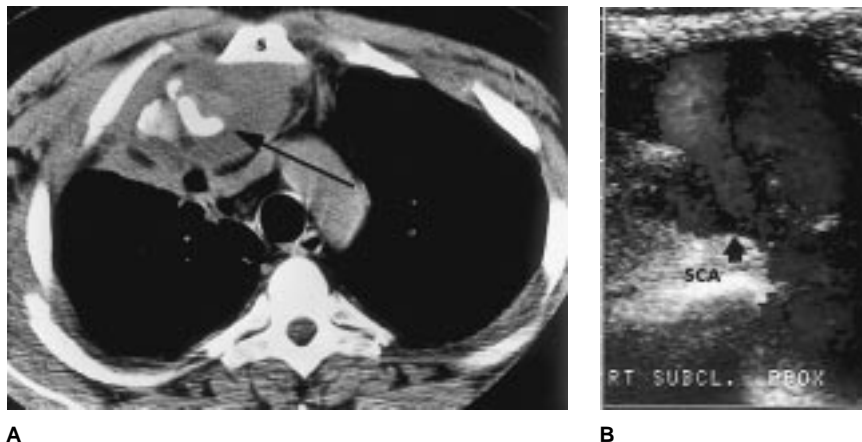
A, CT scan revealing a posterior fracture-dislocation of the sternoclavicular joint with significant soft-tissue swelling and compromise of the hilar structures. Note the comminuted medial-clavicle fracture (arrow). S = sternum. B, Duplex ultrasound study revealing a large pseudoaneurysm of the right subclavian artery (SCA). Note the large neck of the pseudoaneurysm, which measured approximately 1 cm in diameter (arrow). (Reprinted with permission from Rockwood CA Jr, Wirth MA: Injuries to the sternoclavicular joint, in Rockwood CA Jr, Green DP, Bucholz RW, et al [eds]: *Rockwood and Green's Fractures in Adults*, 4th ed. Philadelphia: Lippincott-Raven, 1996, vol 2, p 1439.)
